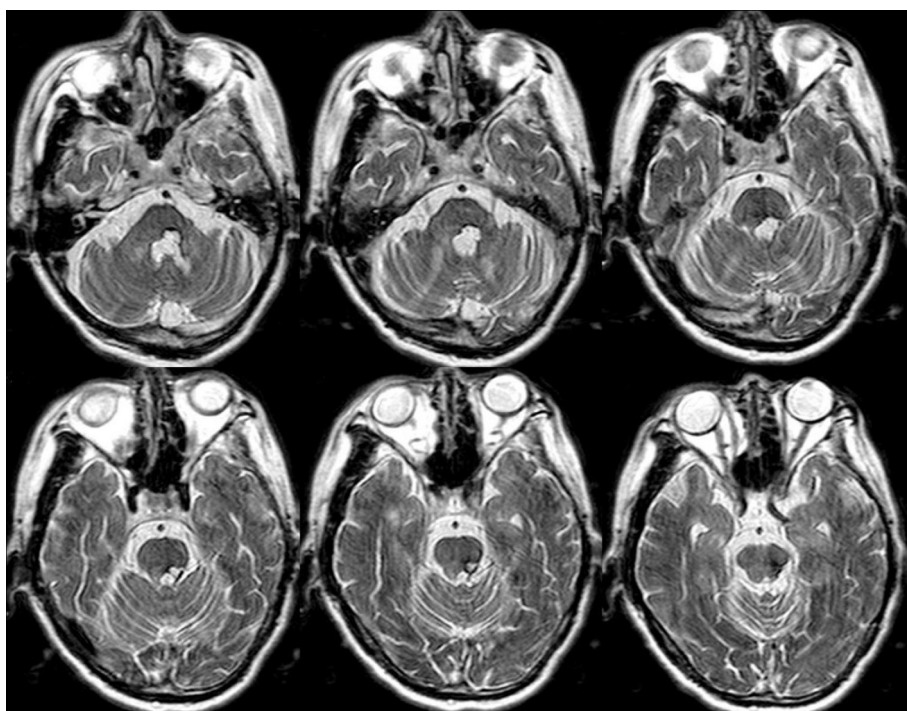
Preoperative T2-weighted axial magnetic resonance imaging revealing the resolution of acute hemorrhage. Encephalomalacic changes, cystic degeneration, and hemosiderin around the lesion were also observed.
